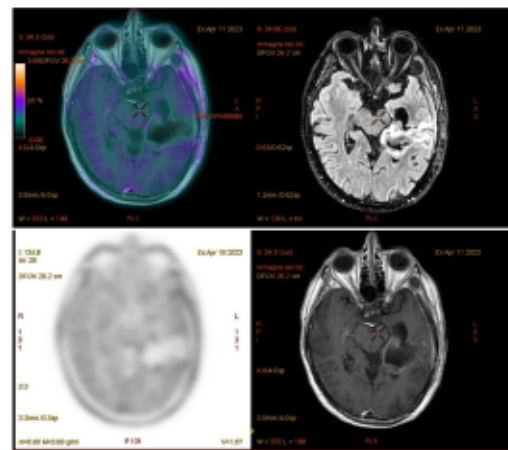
18F-FET-PET and MRI.
